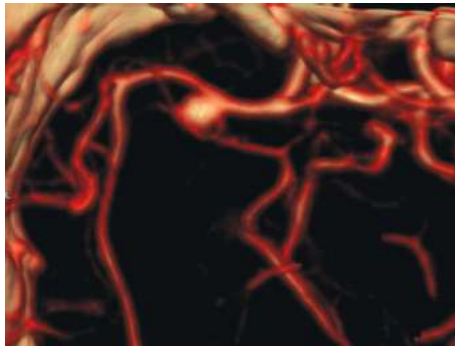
Computed tomography angiography—right M1 aneurysm
